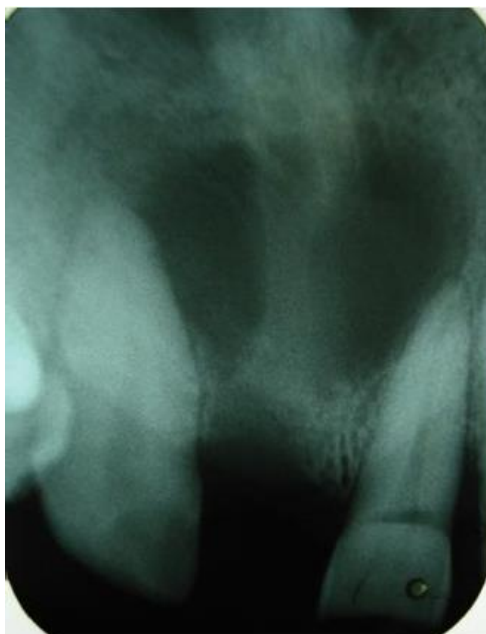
Intraoral periapical radiograph showing a residual cyst associated with anterior maxillary teeth 11 and 21.
